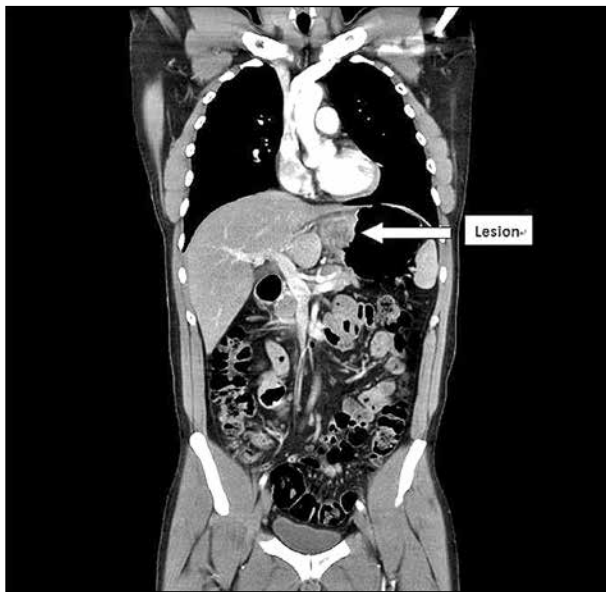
Chest and abdominal computed tomography showed a mass with heterogeneous density at the gastric cardia
